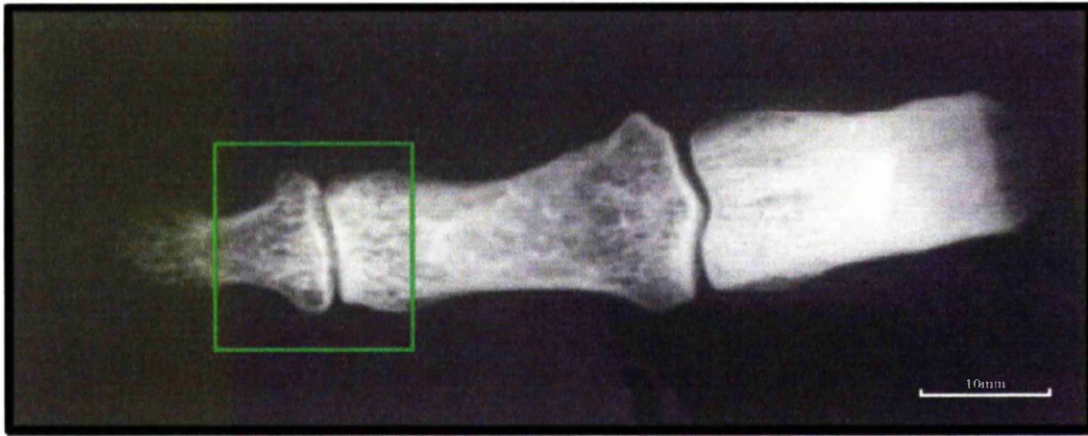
Radiograph of control finger in posteroanterior plane. Distal interphalangeal joint is highlighted.
